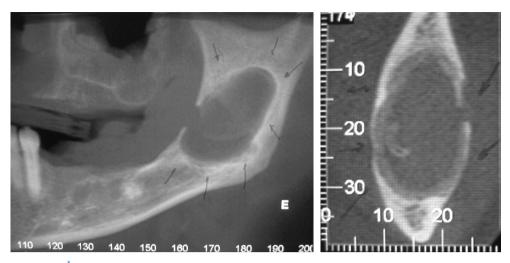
A: Bone CT scan showing cortical rupture of the alveolar bone and a content with heterogeneous pattern. B: Parasagittal scan showing a heterogeneous aspect and the bone rupture of the anterior wall of the mandibular ramus.
